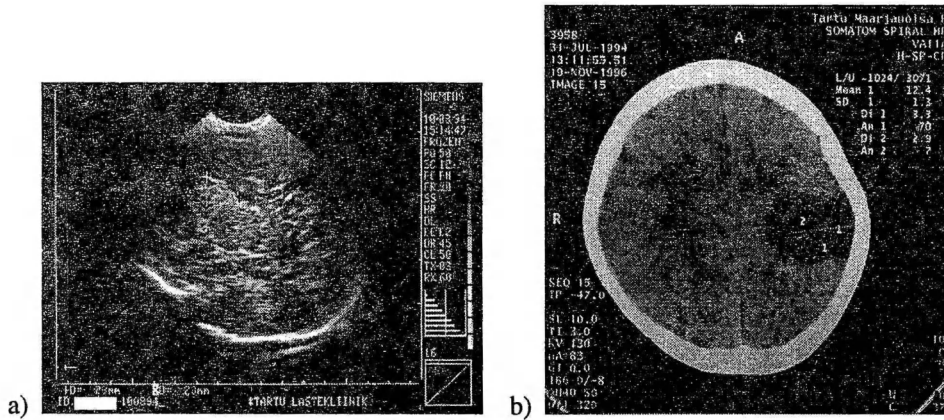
Ultrasound and CT scans of a severely asphyxiated newborn infant with a moderate stage of HIE, with hemiparesis on follow-up.
